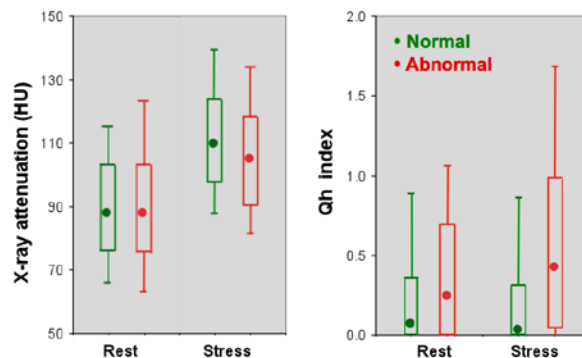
Box-plot summary of myocardial x-ray attenuation (left) and the 3D quantitative index Qh of severity and extent of perfusion abnormality (right) obtained at rest and peak stress separately for myocardial segments supplied by coronary arteries with (red) and without (green) significant stenosis.
